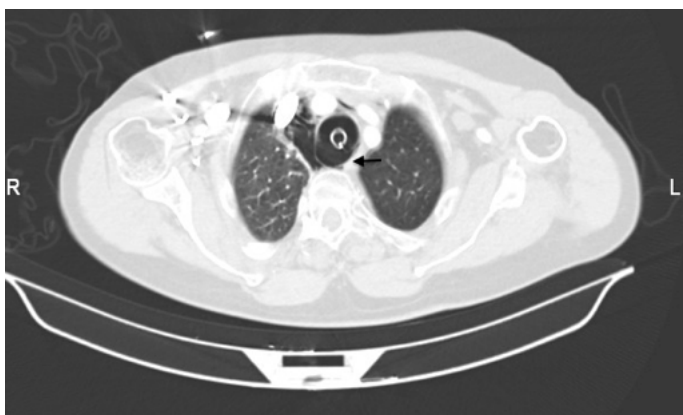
Chest CT scan; CT of the chest showed small volume pneumomediastinum, and a large posterior tracheal rupture in the pars membranosa (black arrow points the large rupture).
